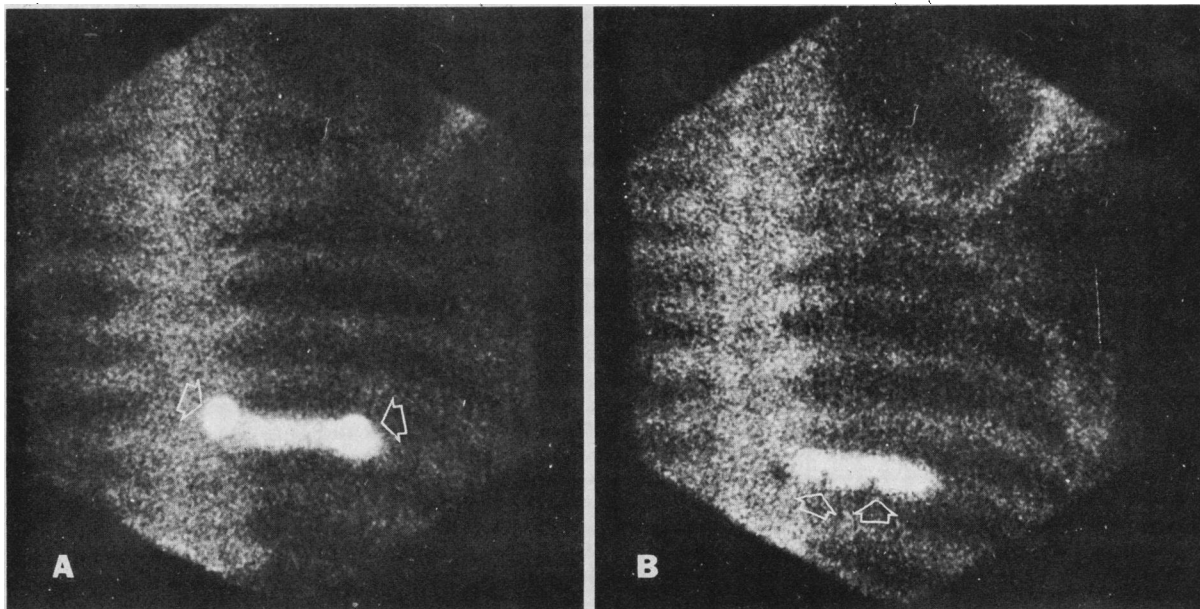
A rib abnormality which was the solitary lesion on scan in a 57-year-old man with cancer of the prostate. A, technetium markers (shown by arrows) were used to position the lesion. Skin marks were then placed in the exact site of the technetium 99m markers as a guide for biopsy. If this technique is employed, great care must be taken to ensure that the patient is in exactly the same position for biopsy as for the scan. B, lead markers, which appear as small photopenic areas indicated by arrows, were placed over the abnormal rib. When lesions are marked in this fashion a standard radiograph will then define the exact site of the lesion. Ribs are not easy to count on scan, because the 1st and 12th ribs may be difficult to identify.
